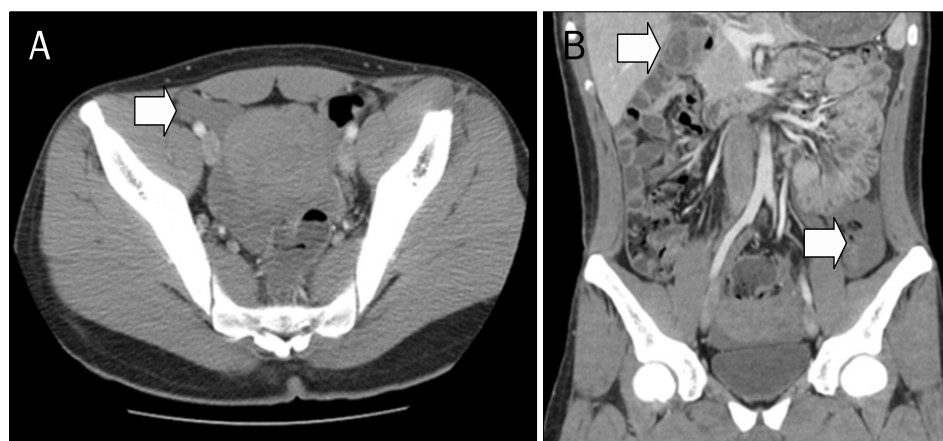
Abdominal CT showed hyper-attenuated fluid collections (Hounsfield unit: 40-60) in the anterior aspect of the sigmoid colon of the pelvic cavity, both paracolic gutters and right subhepatic space, suggesting intraperitoneal hemorrhage (arrow: A, axial image; B, reformatted coronal image).
